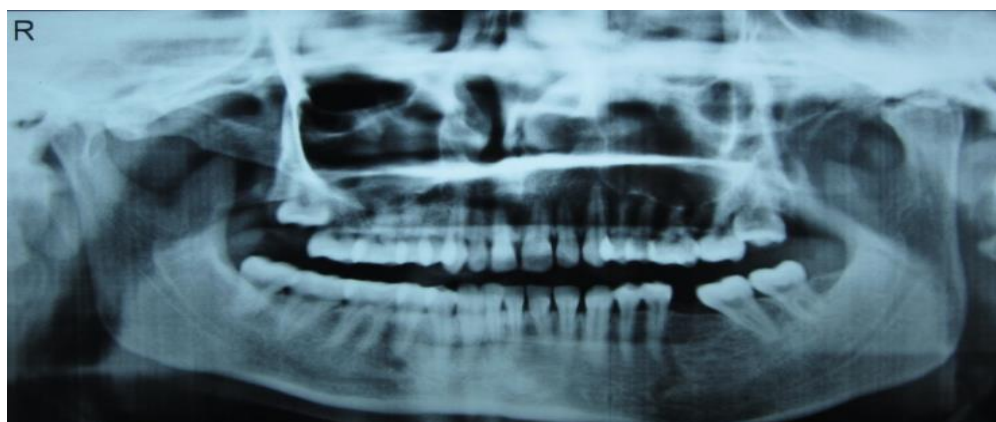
Digital panoramic radiograph increase in size of condylar head and neck irt left side when compared to right side. Shallow sigmoid notch, increased ramal length, increase in superio inferio height of body of mandible appreciated on left side. Inferior alveolar canal lowered in position when compared to right side. Missing tooth noted irt 36 with mesial migration of 37
